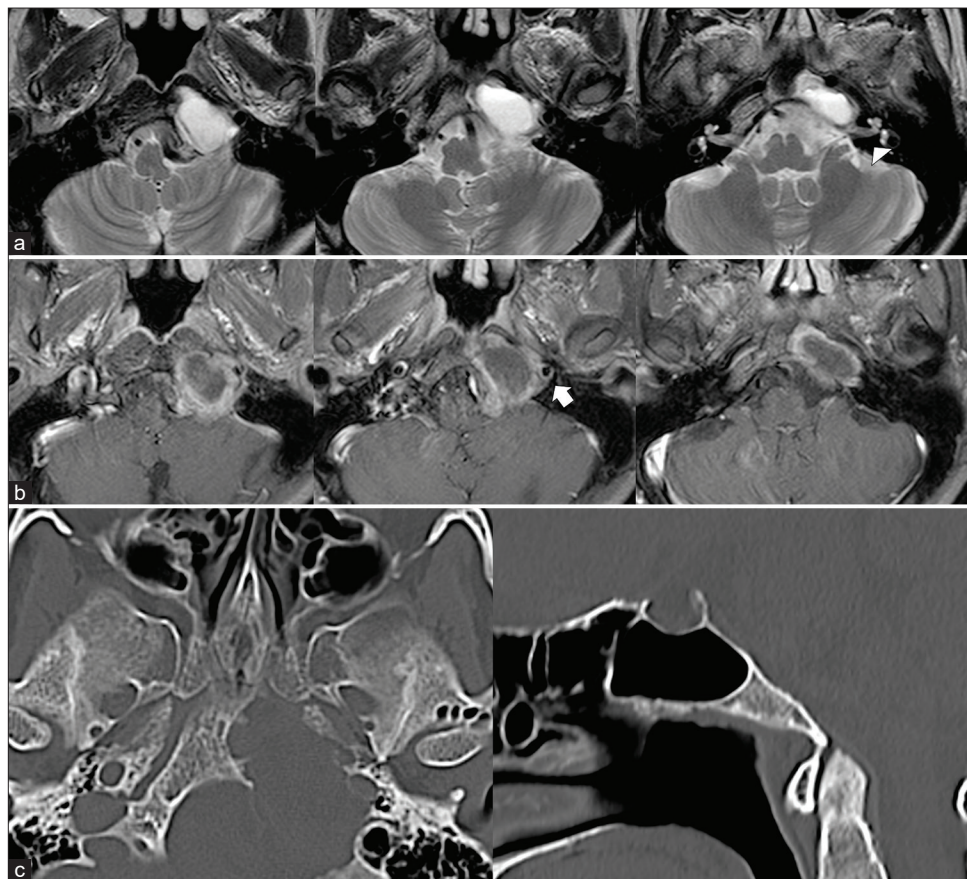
Preoperative head magnetic resonance (a: T2-weighted images and b: gadolinium-enhanced T1-weighted images) and computed tomography images (c: left, axial images; right, sagittal images). (a and b) The cystic tumor tumoral lesion is located on the left side of the clivus, showing ring enhancement with gadolinium contrast. The lesion extends into the intracranial space, compressing the brain stem and left internal carotid artery (white arrowhead: internal auditory canal, white arrow: internal carotid artery). (c) The tumor has invaded the left side of the clivus.
